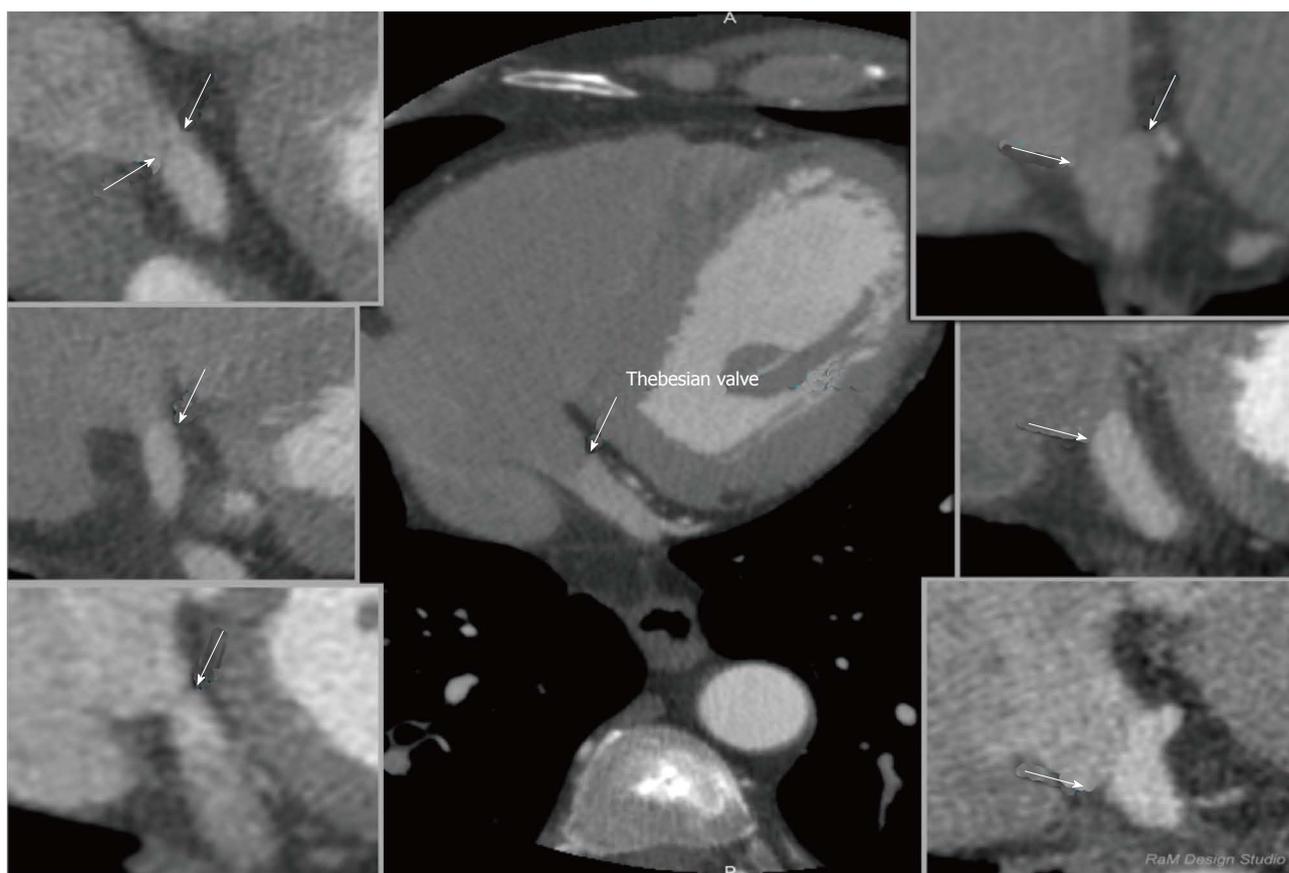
Examples of thebesian valves in cardiac computed tomography; two-dimensional multi-planar reformatting projections.
